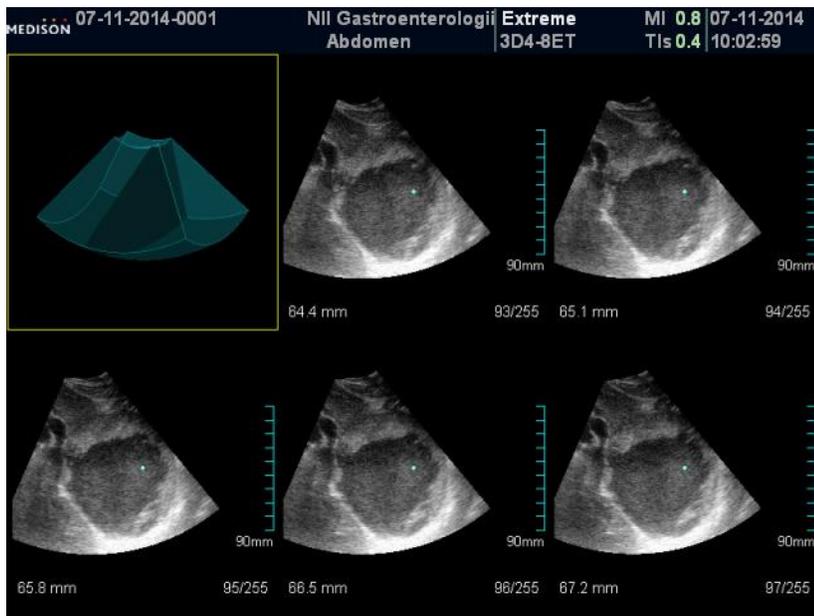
Transabdominal ultrasound, 3D mode, the function multislice step cut of 0.7 mm — bond formation with pancreatic parenchyma.
